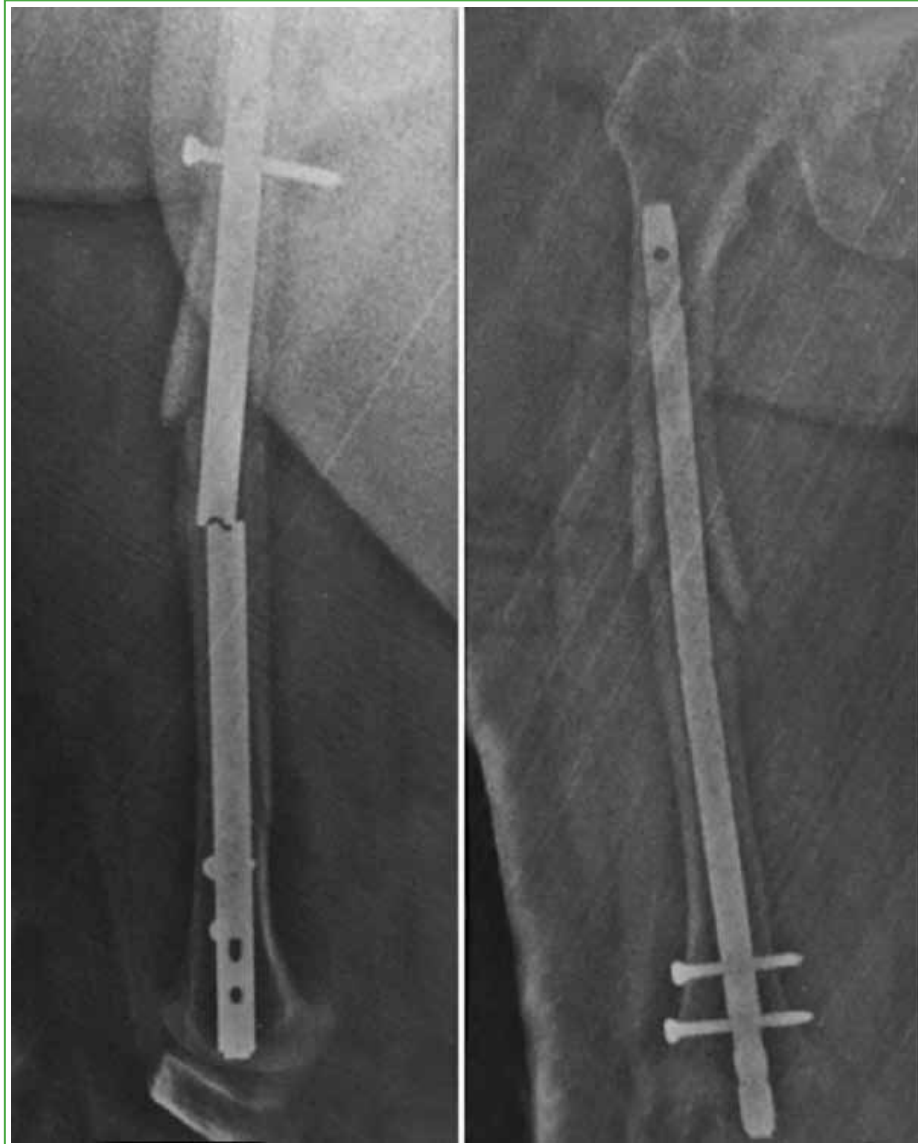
Anteroposterior and lateral radiographs of the right femur upon admission to the Emergency Service. Note the breakage of the intramedullary nail and the nonunion.
